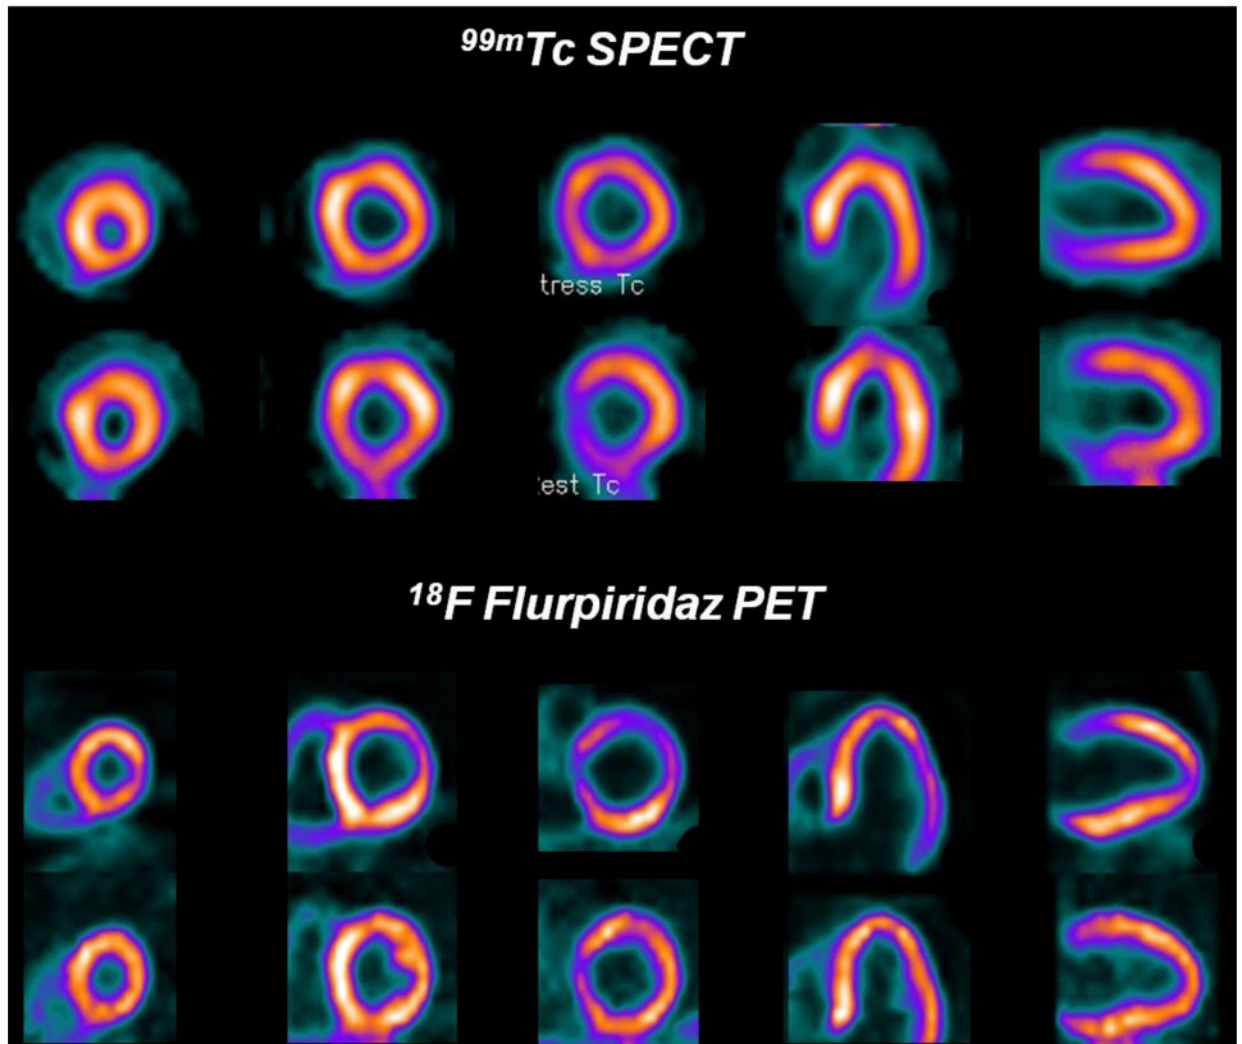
^{99m}Tc SPECT images (upper rows) and flurpiridaz F 18 PET images (lower rows) from a patient with normal coronary arteries. A false positive reversible inferior defect is present on the ^{99m}Tc SPECT images due to shifting soft-tissue attenuation. The flurpiridaz F 18 PET study, however, provided superior image quality and was normal.
